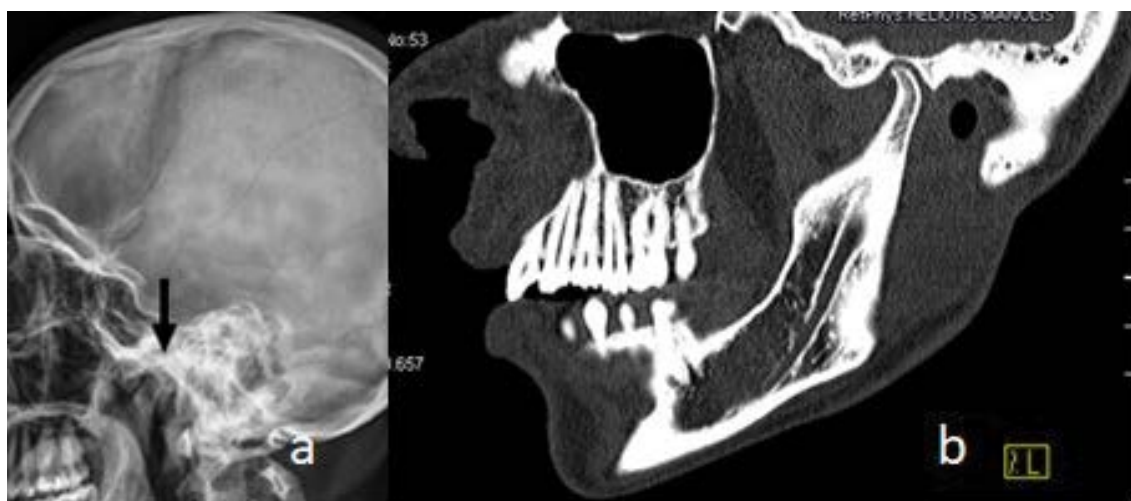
a,b. Lateral skull radiograph showed element of temporomandibular osteoarthritis/derangement (a) (arrow). 3D reformatted CT scan showed dysplastic and progressive narrowing of the disc of the temporo-mandibular joint (TMJ), especially when blocked between the articular eminence and the condyle-arrow (b).
